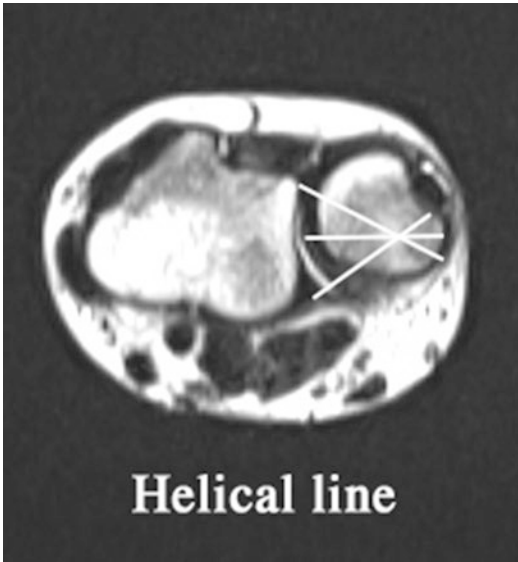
Magnetic resonance imaging scouted by the helical line
